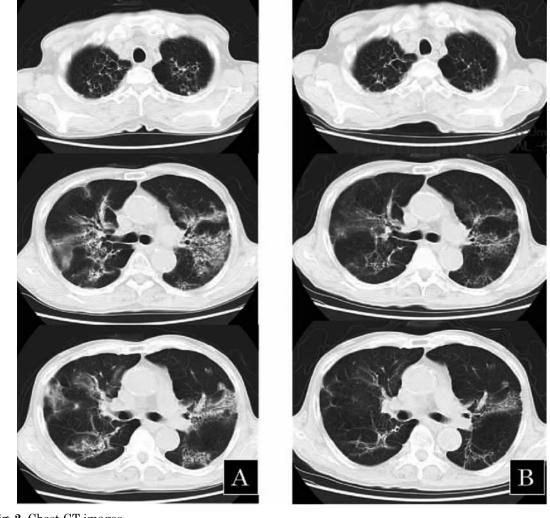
Chest CT images.(A) Bilateral ground-glass and reticular opacities 18 months before esophageal tumors were identified.(B) Bilateral ground-glass and reticular opacities have improved but remain extant at the time of surgery.
